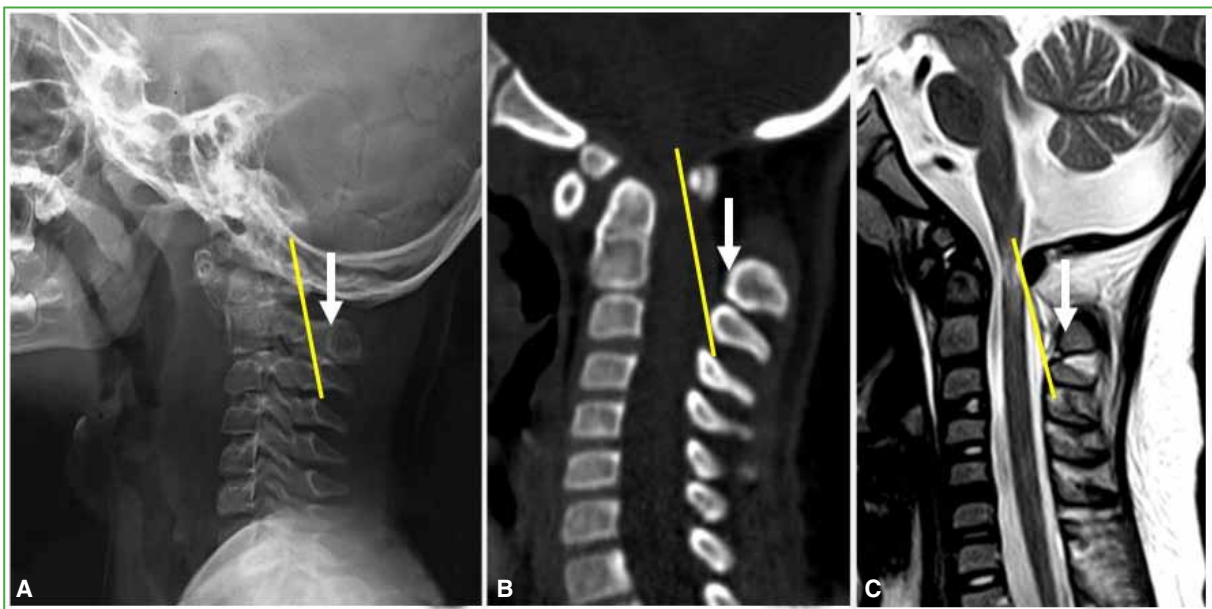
Six-year-old boy with Down syndrome: hypotonia of all four limbs exacerbated by trauma. A-C. Radiograph, CT and MRI of the skull base and upper cervical spine, respectively. The SL tracing shows retroposition of the spinolaminar line of the axis, severe C1-C2 instability, and lack of continuity of the SL with the opisthion. There is significant neuroaxis compression and myelomalacia.
